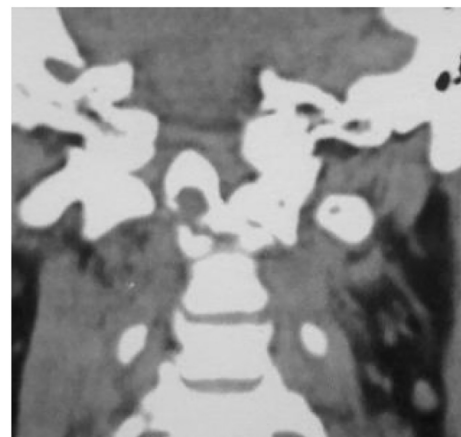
Pre-operative coronal CT neck. Osteolysis of C2 body and odontoid process visible.
